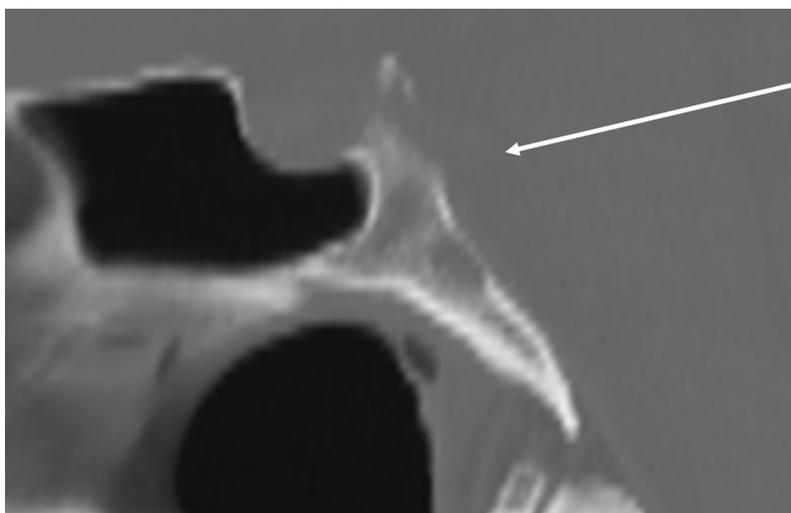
CT head demonstrating lytic lesions of the clivus (arrow)
